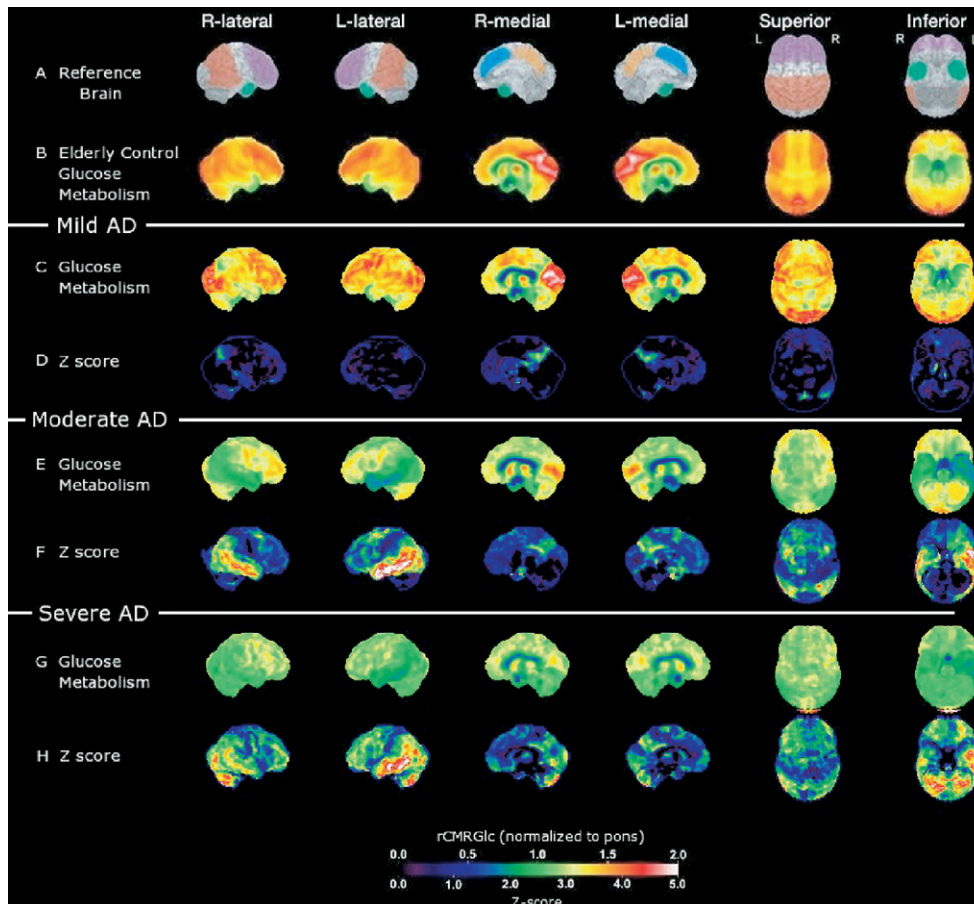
Typical patterns of cerebral metabolism in mild, moderate, and severe AD. FDG-PET scans are displayed as 3-dimensional stereotactic surface projection (SSP) maps normalized to pons generated with the software program Neurostat. Maps are shown with relative cerebral metabolism or statistical significance increasing on the color scale from the lowest values shown in blue to the highest values in red and white. For orientation, a reference brain is shown in row A with regions of interest in dementia evaluations in color; orange areas usually hypometabolic in AD, blue and purple areas typically hypometabolic in FTD. Row B shows the pattern of metabolism in 27 normal elderly subjects. This is used for statistical comparisons with metabolism in individual patients (rows D, F, and H). There are increasing severity and extent of cerebral glucose hypometabolism as AD progresses from mild (rows C and D) and moderate (rows E and F) to severe (rows G and H).
